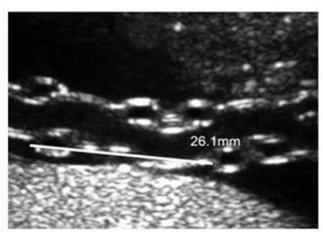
Ultrasound image along the axis of a normocoiled umbilical cord with an antenatal umbilical coiling index (UCI) of 0.35, and intercoil distance of 2.61 cm.
